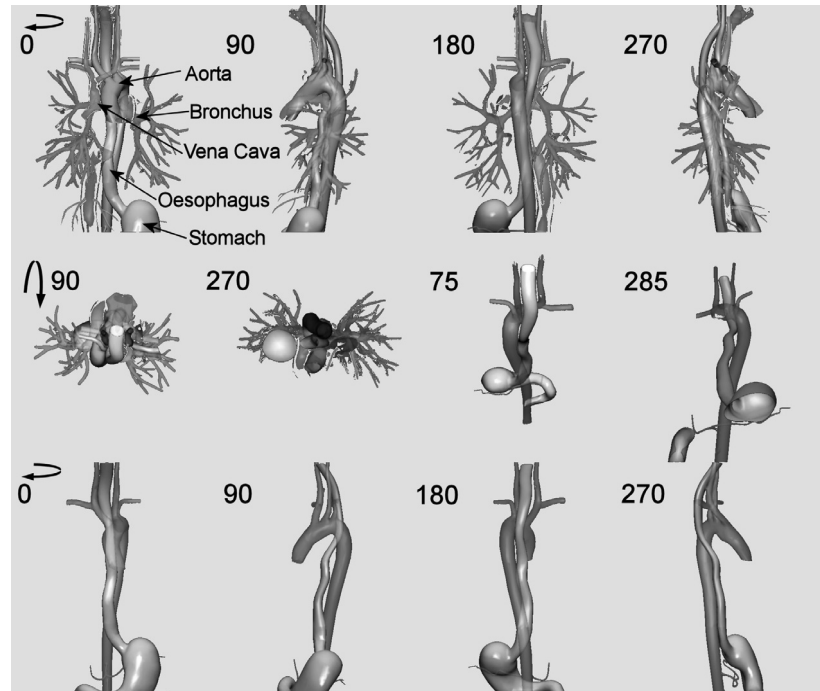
The idealised 3D anatomy of the upper GI tract and aorta. Also included was the bronchus and vena cava. The anatomy was rotated around the axes to visualise the shape of the aorta and oesophagus. Certain organs had transparency applied to them for improved visualisation. The images were captured from the educational DVD, Endoscopic Ultrasound in the diagnosis of thoracic diseases (Olympus Europa GMBH, Hamburg, Germany)
